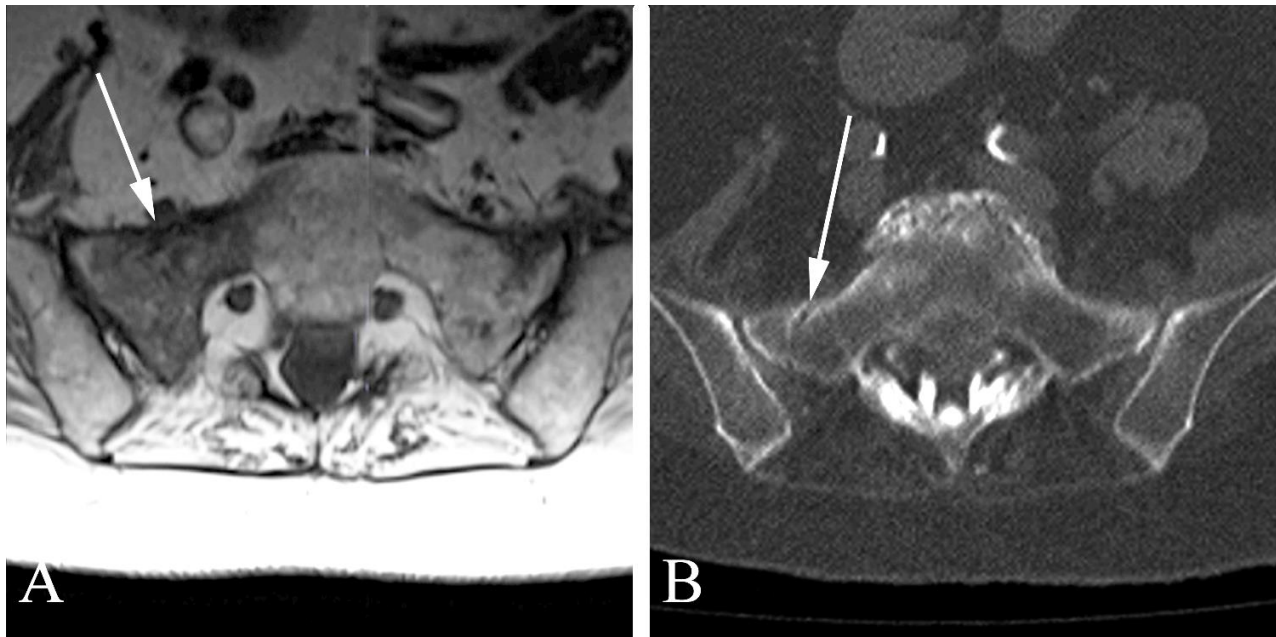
Radiographically occult stress fracture in a 73 year old woman with new pain following a change in exercise routine. A. Axial T1 sacral MR shows abnormal signal within the right sacral ala (arrow). B. Axial CT of the sacrum confirms a fracture lucency (arrow) corresponding to a healing stress fracture of the sacrum.
